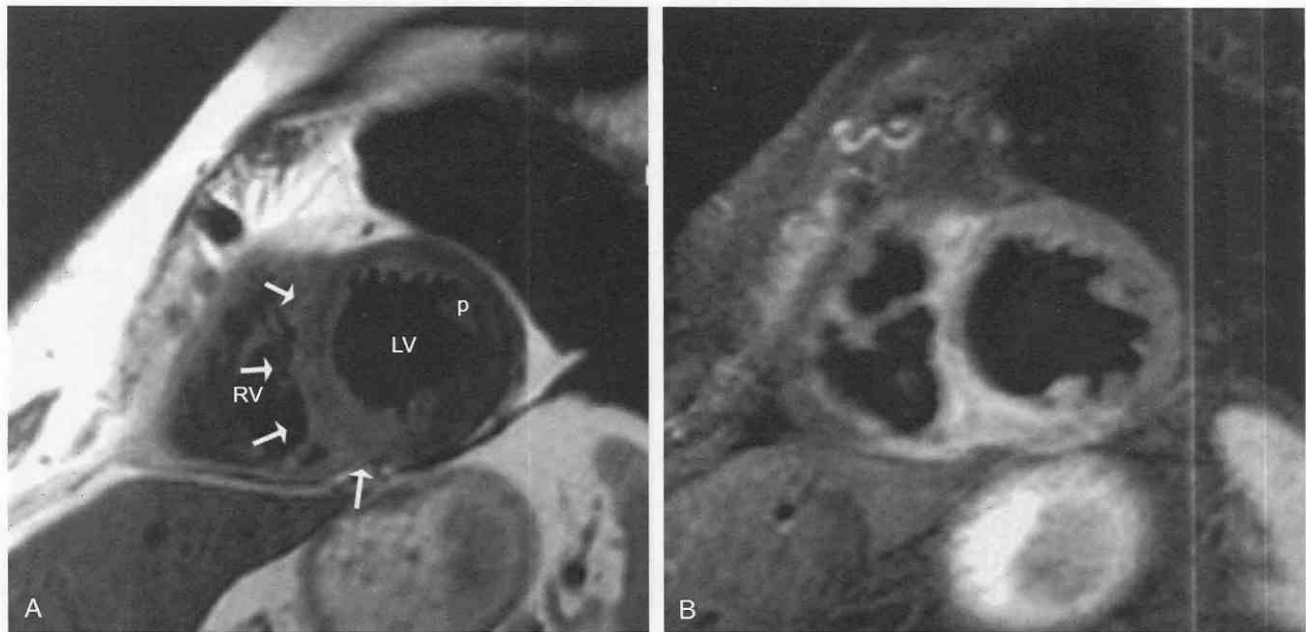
Short-axis images obtained from a 58-year-old man with an acute anterior myocardial infarction. A, T1-weighted image shows the normal appearance of the left ventricular (LV) and right ventricular (RV) chambers but a relative increase in signal intensity (arrows) of the interventricular septum and inferior LV myocardium. The papillary muscle (p) is labeled. B, T2-weighted image obtained at the same anatomic level exaggerates the increased signal intensity of the regional myocardial edema.
